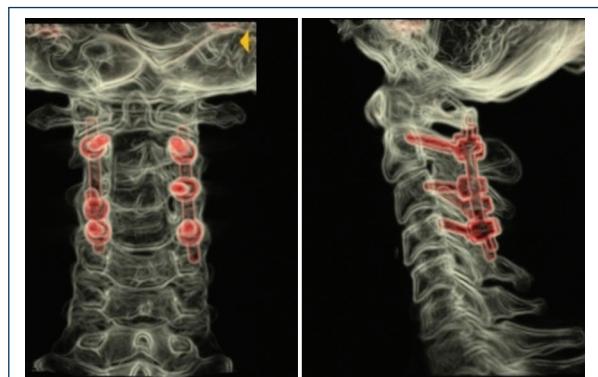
Post-operative computed tomography with metallic suppression showing the arrangement of screws and rods.
